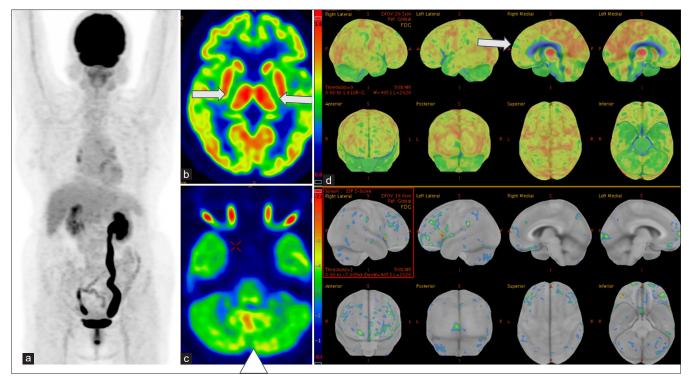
F-18 FDG PET maximum intensity projection image shows that (a) no focal metabolically active lesion has been identified. Transaxial plain FDG PET image of the brain (b) at the level of BG reveals BG hypermetabolism and (c) occipital hypometabolism. Cortex ID maps showing minimal prefrontal hypometabolism (d). BG: basal ganglia, PET: positron emission tomography, ID: identification, FDG: fluorodeoxyglucose
